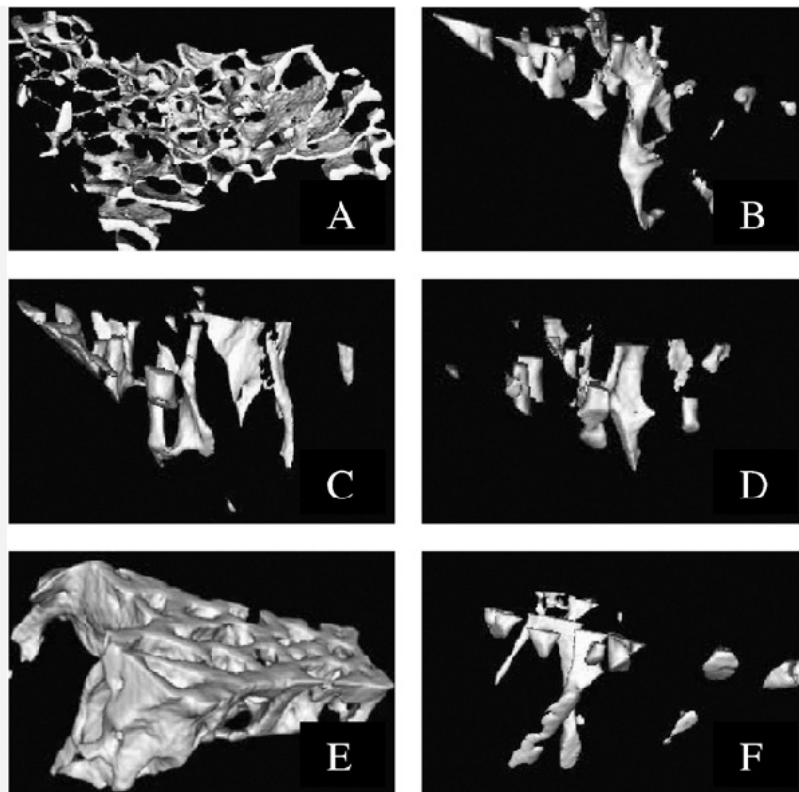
Three-dimensional μ CT images of the tibia trabecular. A: WT; B: Gen; C: E(2); D: DMSO; E: ZoL; F: H₂O.
